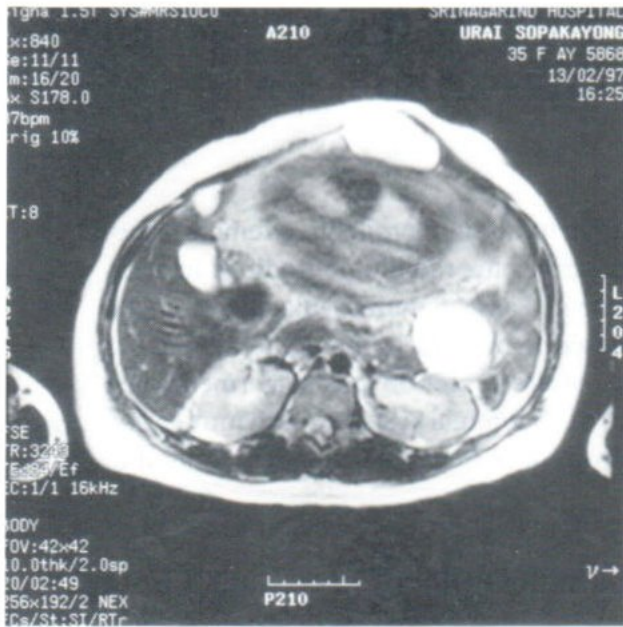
Axial T2-weighted FSE (TR/TE = 3243/84) revealed 4 x 3 cm intra-abdominal cystic lesion attached to peritoneum anteriorly.
